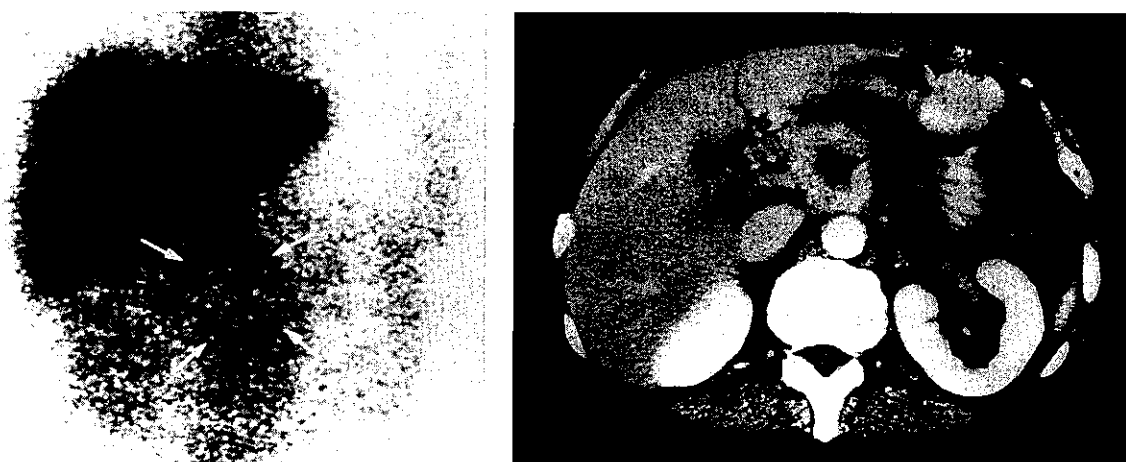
Anterior planar scintigram with $^{111}\text{In-Nd2}$ and enhanced CT scan in a patient with primary pancreatic cancer (patient 4). The scintigram reveals positive RAID corresponding to the pancreatic tumor (arrow) detected in the CT scan, accompanied with central necrosis.
